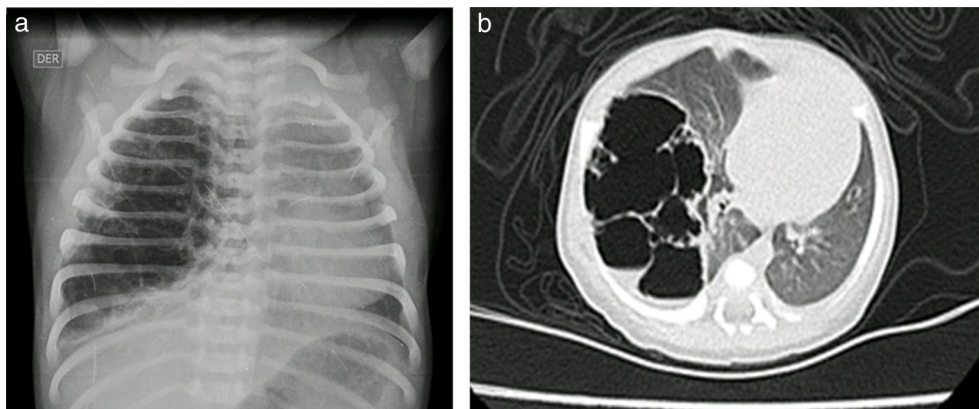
(a and b) Pre-surgical chest X-ray and CT case no. 1.
